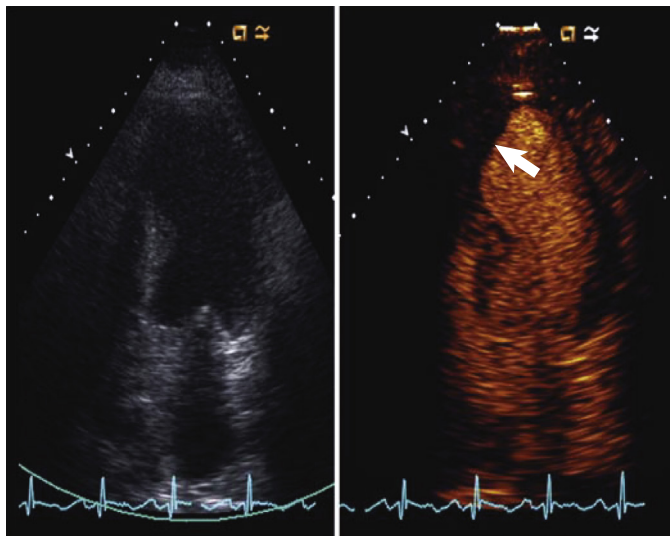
Unenhanced (left) and contrast-enhanced (right) apical four-chamber systolic images. In the unenhanced image it is impossible to define the endocardium, whereas with contrast enhancement the endocardium is clearly delineated and the straight margin characteristic of a sessile apical thrombus (arrow) is appreciated.
